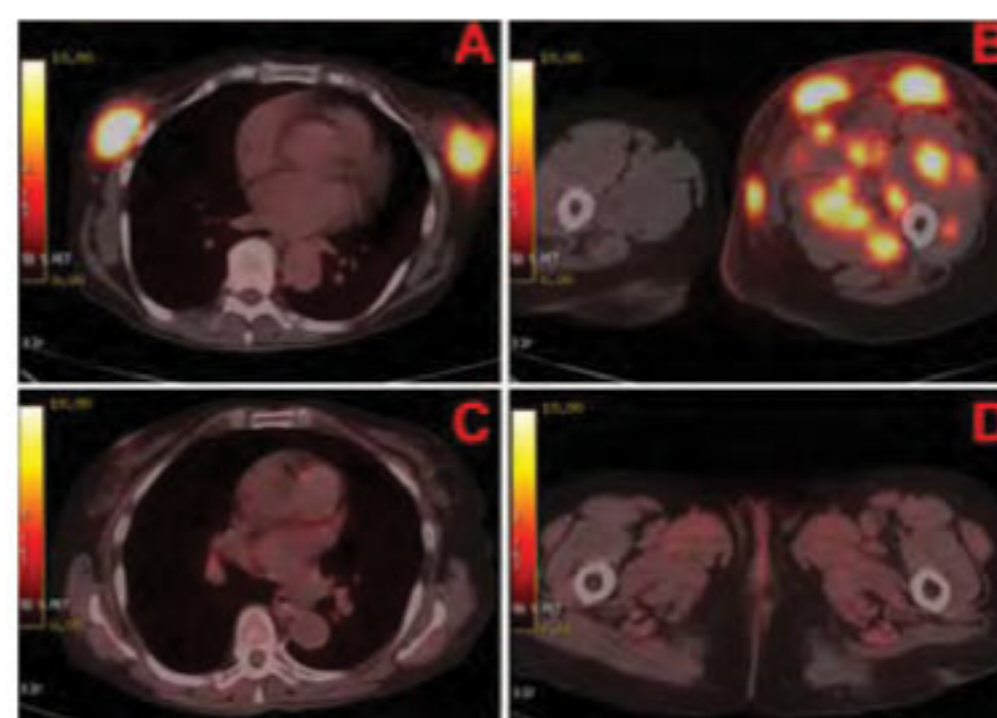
Pre treatment cross sectional images of ¹⁸F-FDG-PET/CT showing intense ¹⁸F-FDG uptake in bilateral breasts (A) and subcutaneous nodules in left thigh (B). Post treatment cross sectional images of ¹⁸F-FDG PET/CT of the same patient after 4 cycles of R-CHOP chemotherapy show complete disappearance of abnormal ¹⁸F-FDG uptake in bilateral breasts (C) and subcutaneous soft tissue nodules in the left thigh (D) indicating complete metabolic response to chemotherapy.
